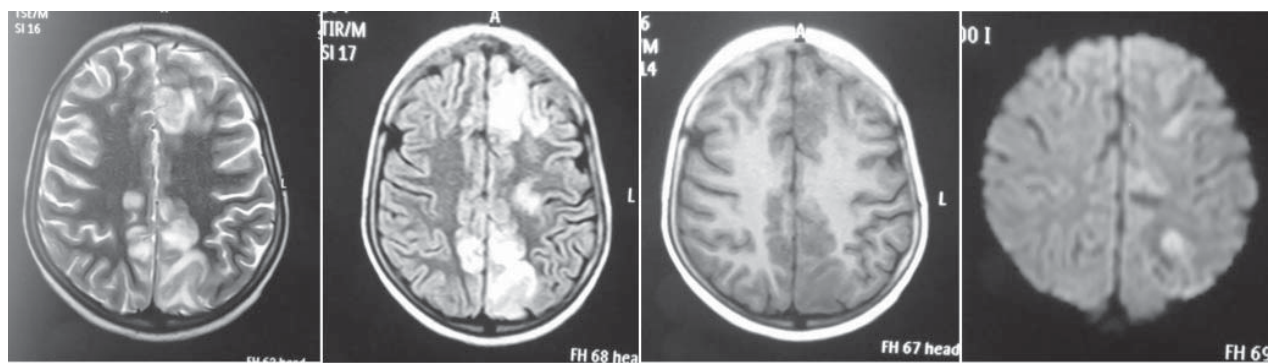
MRI brain contrast images showing asymmetric cortical and subcortical altered signal intensities in bilateral singulate gyrus, right occipital, bilateral parietal and bilateral high fronto-parietal lobes
